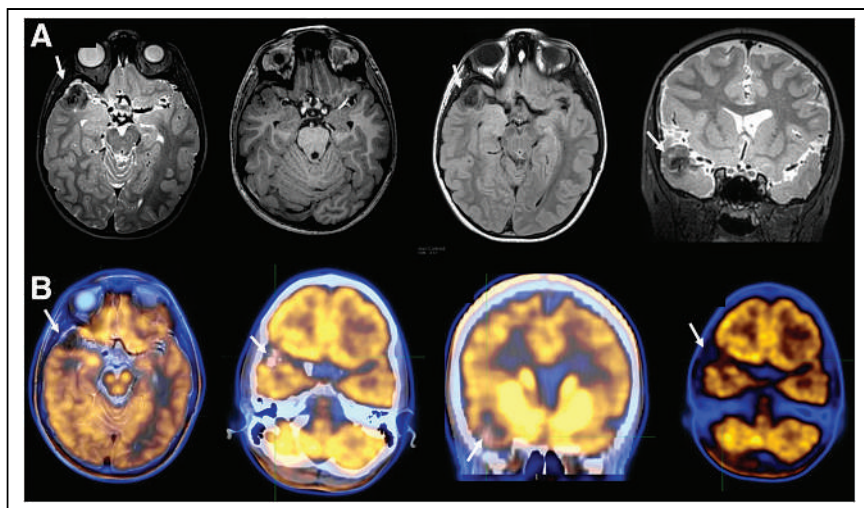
No ^{18}F -DOPA uptake in calcified benign right temporal lesion (meningioma) (arrows). (A) From left to right: axial T2-weighted, axial T1-weighted, axial fluid-attenuated inversion recovery, and coronal T2-weighted MR images. (B) From left to right: axial ^{18}F -DOPA PET/MR, axial ^{18}F -DOPA PET/CT, coronal ^{18}F -DOPA PET/CT, and axial ^{18}F -DOPA PET images.
